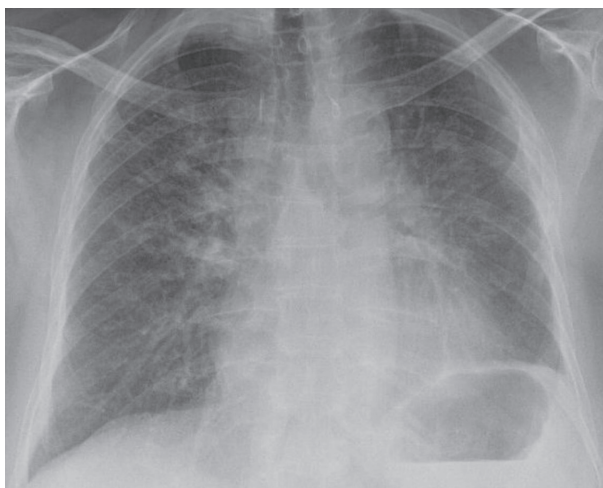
Chest radiography; reticulonodular opacities in both lung fields, elevated left hemidiaphragm
